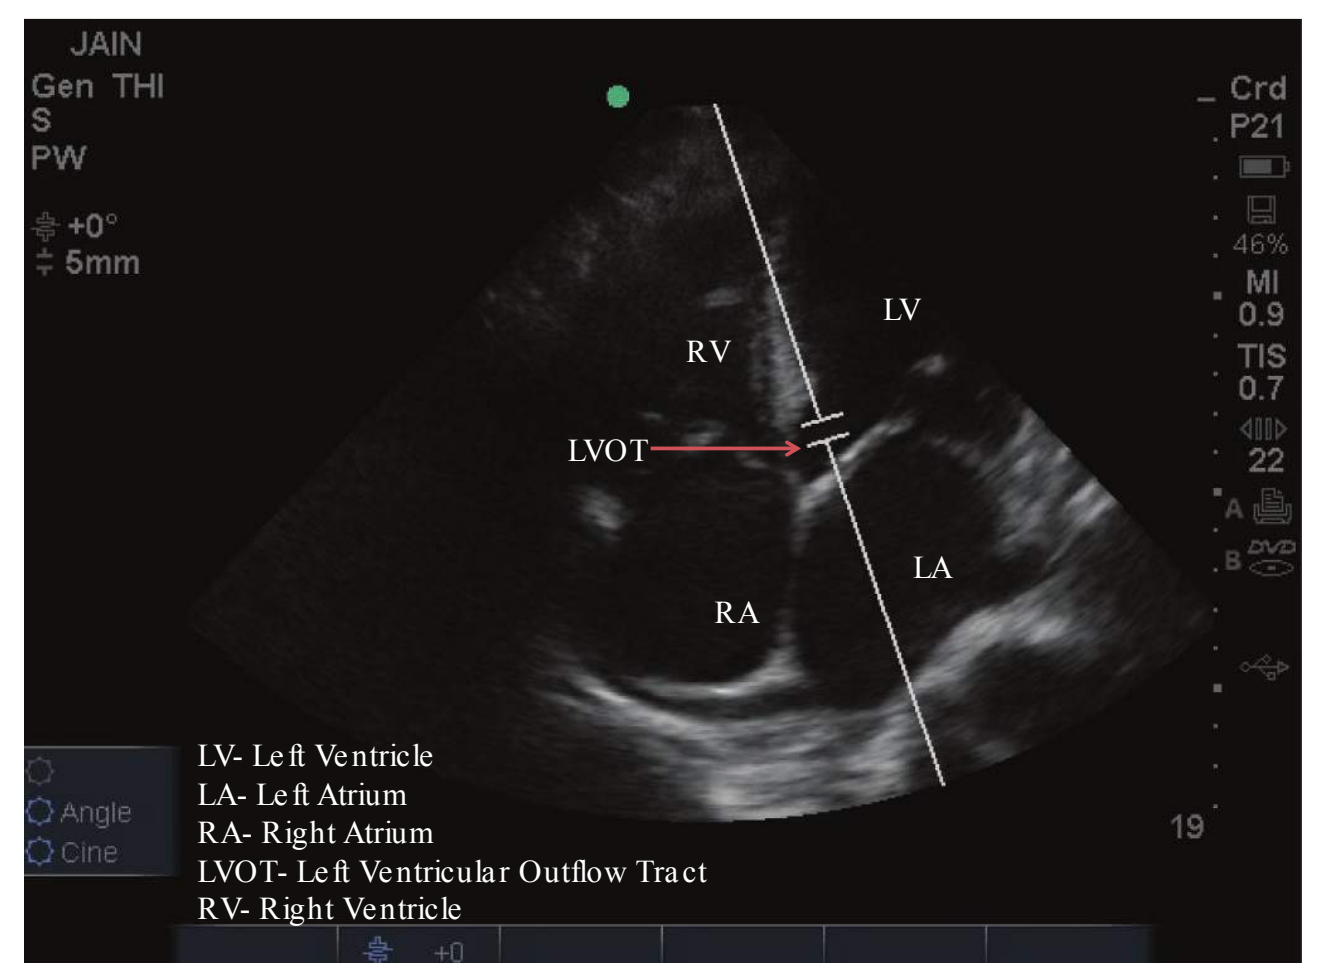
Apical five-window with Doppler gate in the left ventricular outflow tract (LVOT) for LVOT velocity time integral (VTI).
